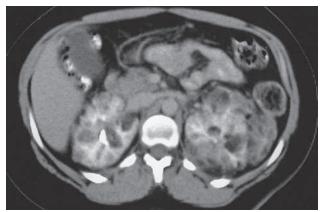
Radiologic findings associated with tuberous sclerosis complex. Contrast-enhanced CT showing bilateral angiomyolipomas.
